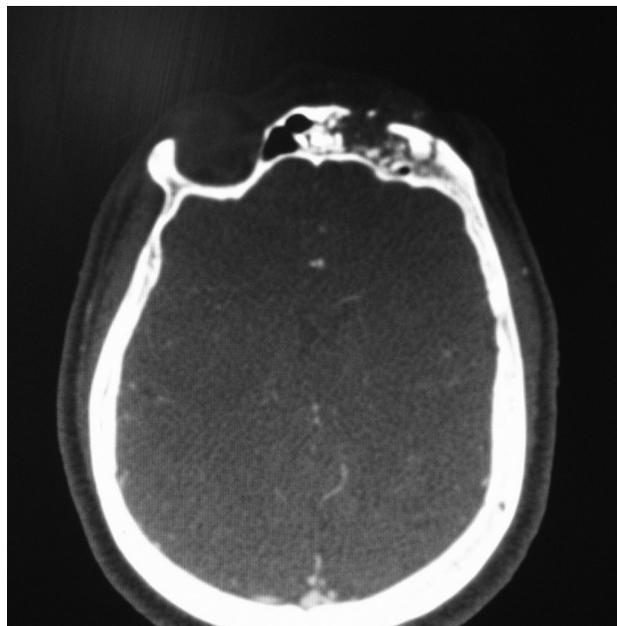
CT (computed tomography) maxillofacial demonstrating a comminuted left frontal sinus fracture with an intrasinus foreign body.
